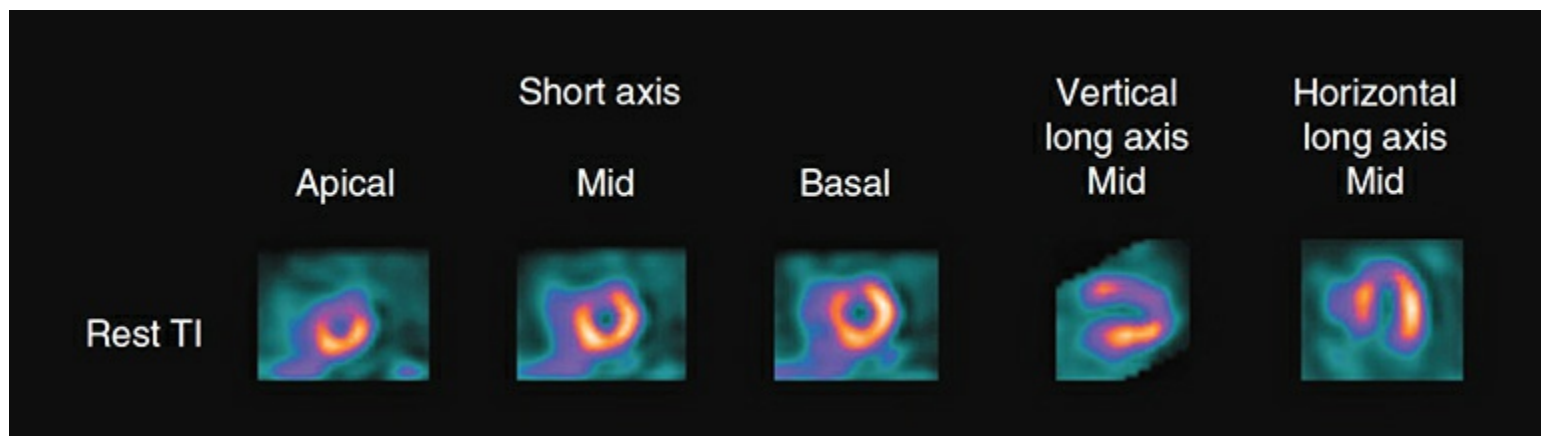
Rest thallium-201 (^{201}Tl) single-photon emission computed tomography (SPECT) myocardial perfusion imaging (MPI) showing a large amount of resting ischemia in the left anterior descending. The stress SPECT-MPI study was canceled in this patient because of the unexpected perfusion defect.
